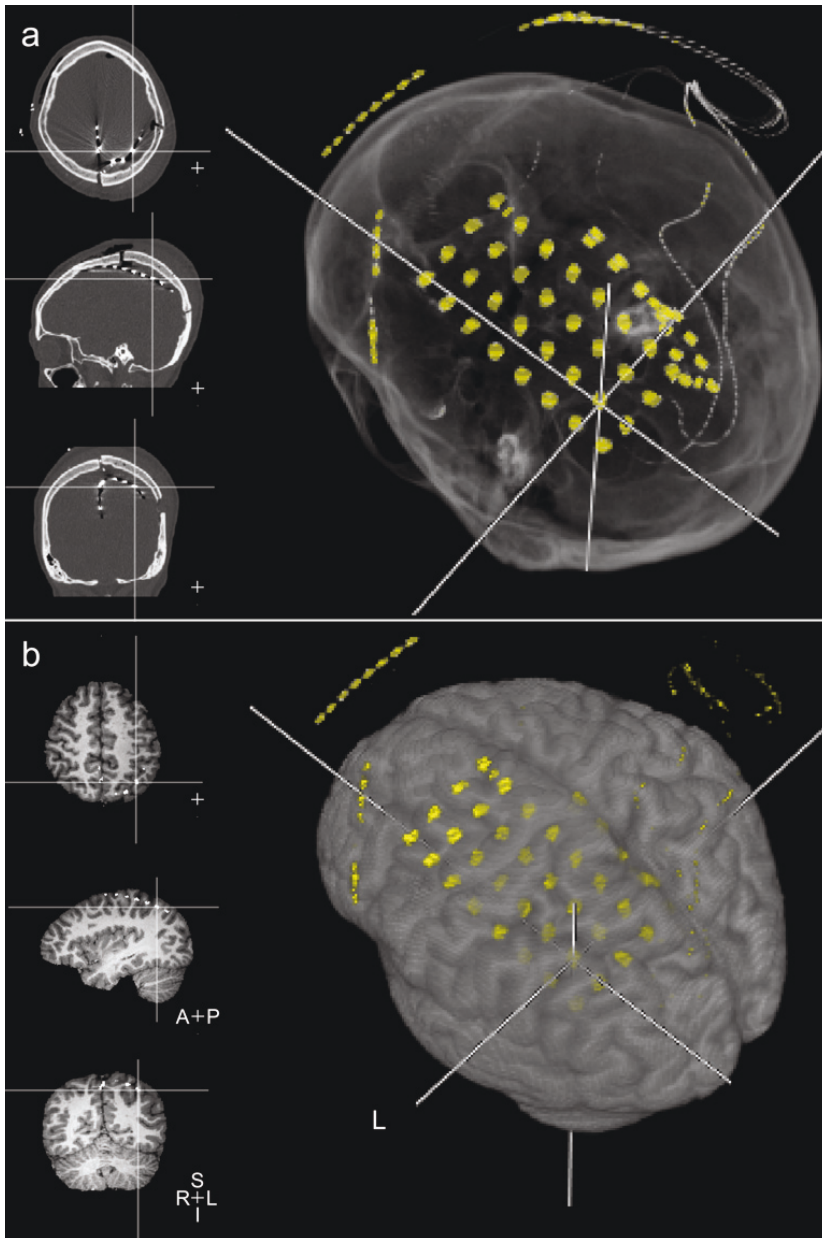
a) An example of the localization of the subdural electrodes from post-operative CT images, in different orientations and in 3-D volume rendering. The opacity transfer function is adjusted to show the electrodes in the 3-D reconstruction, which are also highlighted with yellow in the 3-D volume rendering. b) The preoperative cortical MR segmentation in different orientations and in 3-D volume rendered image. The CT is registered to the preoperative MR and the electrodes are transferred to it as high intensity objects (highlighted with yellow in the 3-D volume rendering). The centers of relevant electrodes (one shown with a crosshair in the images) were manually pointed from the 3-D volume rendered images for the distance parameter calculations.
